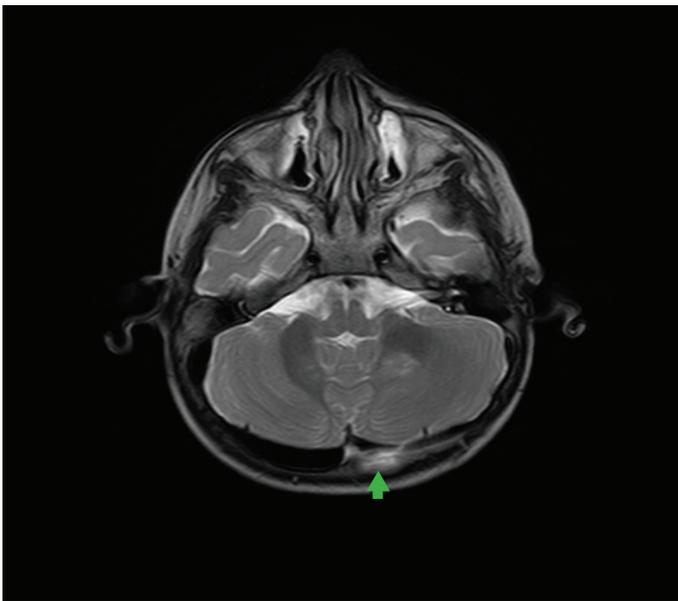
MRI Brain – green coloured arrow mark shows contusion of left middle cerebellar peduncle.
